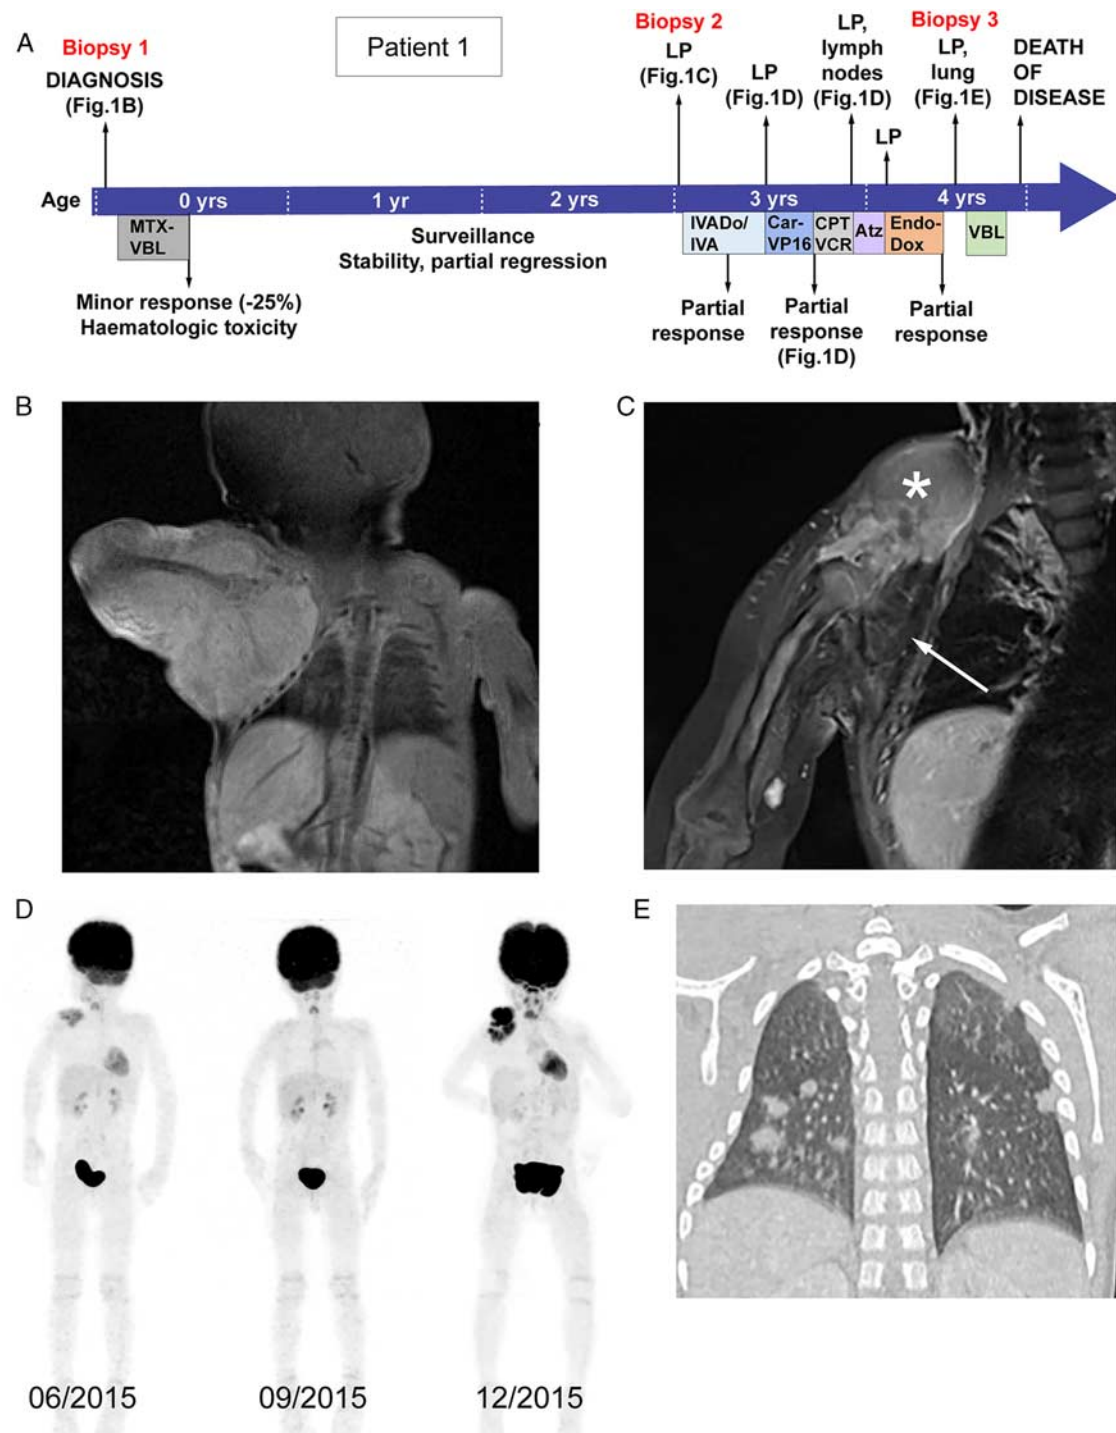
Clinical history and selected imaging for patient 1. A, Clinical timeline. B, Coronal proton density-weighted fat-saturated MRI at diagnosis, showing a soft-tissue mass of the right shoulder girdle. C, Coronal T1-weighted contrast-enhanced MRI, showing the residue (arrow) with tumor progression in the upper portion of the lesion (asterisk). D, Whole-body ^{18}F -FDG PET images at 3 different timepoints; left: upon local progression on the IVA regimen—moderate uptake of the right shoulder lesion, maximum standardized uptake value (SUV_{max}) = 3.6; middle: after 3 doses of carboplatin-etoposide—excellent metabolic response with resolution of uptake, barely distinguishable from the surrounding background, SUV_{max} = 1.4; right: 3 months later—local progression with a highly metabolic lesion of the right shoulder area, SUV_{max} = 11, and homolateral supraclavicular lymph node extension. E, Coronal computed tomography image showing bilateral lung metastases. Atz indicates atezolizumab; Car-VP16, carboplatin-etoposide; CPT-VCR, irinotecan-vincristine; Endo-Dox, endoxan-doxorubicin; IVA, ifosfamide-vincristine-actinomycin D; IVADo, ifosfamide-vincristine-actinomycin D-doxorubicin; LP, local progression; MTX-VBL, methotrexate-vinblastine; VBL, vinblastine.
